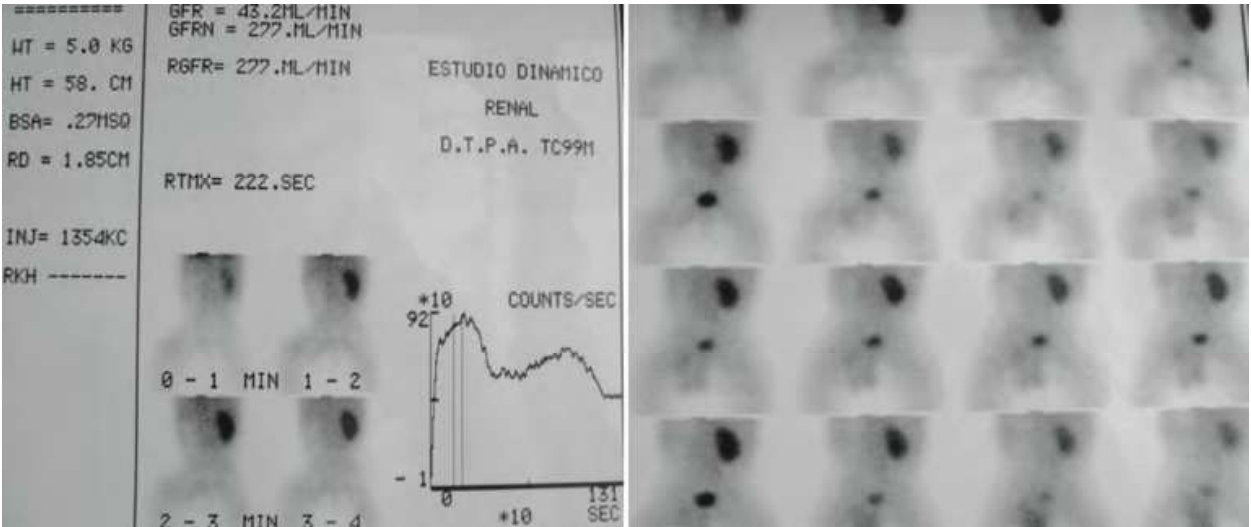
Renal scintigraphy. All the kidneys removed showed renal function lower than 10% in D.T.P.A. (Parenchymal imaging with Tc 99mDMSA provide an excellent picture of functional parenchyma or defects indicating nonfunctioning parenchyma, but it has the inability to assess the excretory phase of renal function that makes impossible distinguish MCDK from hydronephrosis caused by UPJ obstruction).
